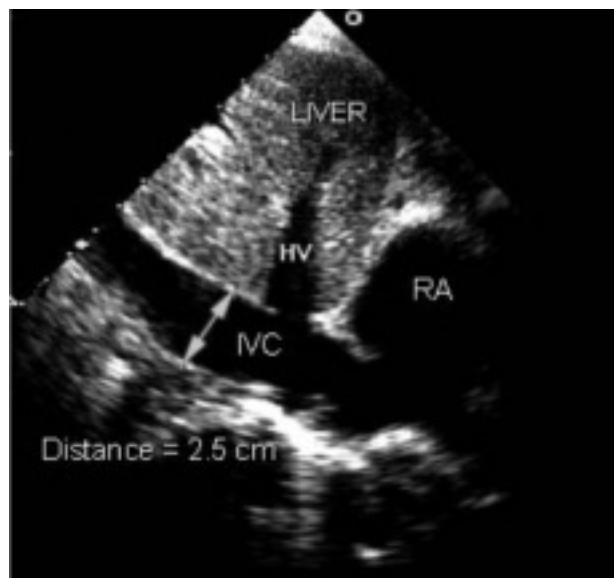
Indirect assessment of circulating volume status on 2D echocardiography by assessing the diameter and change in caliber with inspiration of the inferior vena cava (IVC). This method has been shown to discriminate reliably between RA pressures < 10 mm Hg or > 10 mm Hg. A dilated vena cava (> 20 mm) without the normal inspiratory decrease in caliber ($> 50\%$ on gentle sniffing) usually indicates elevated RA pressure. A small vena cava will reliably exclude elevated RA pressure in these patients. In the above case, the inferior vena cava was dilated at 2.5 cm with minimal respiratory variation in a spontaneously breathing patient. The RA pressure was thus estimated to be approximately 10 to 15 mm Hg. Images were obtained in the subcostal view. HV = hepatic veins.
